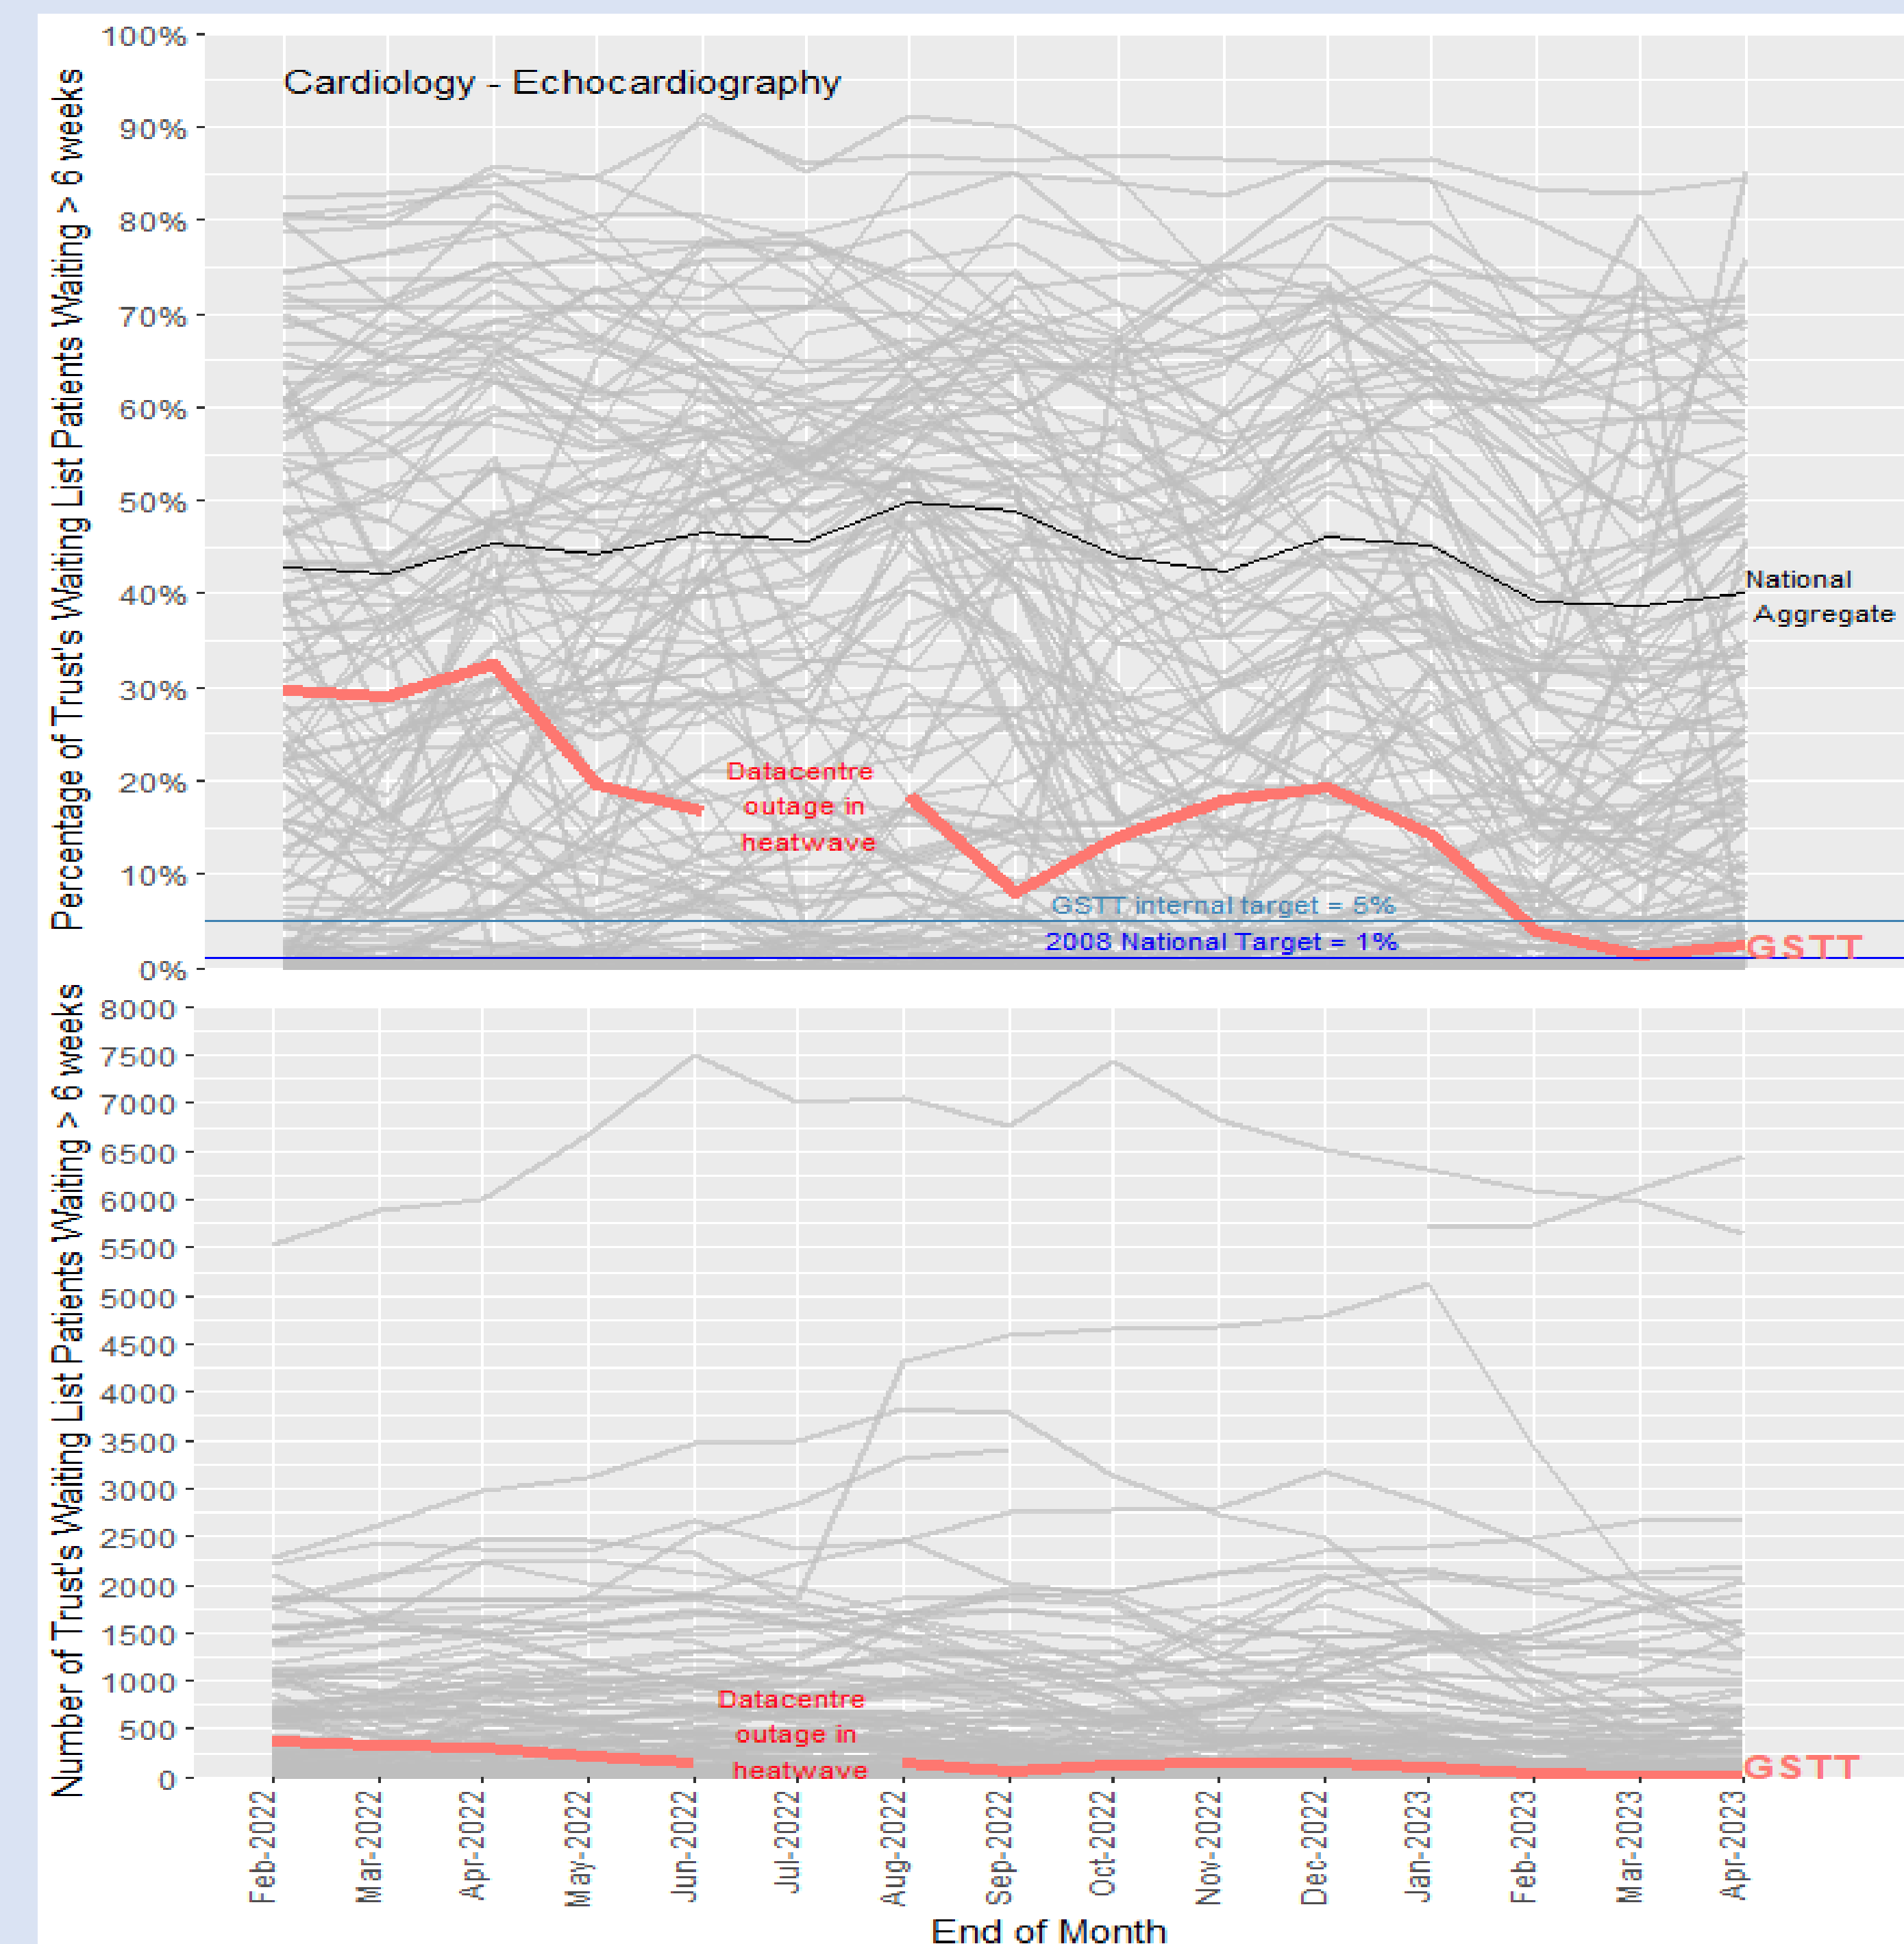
National Diagnostic set data. Each line is the performance of an NHS trust [N=134] on the 6-week-wait benchmark as a % of the Echocardiography waiting list (top) and the number of patients (bottom).
